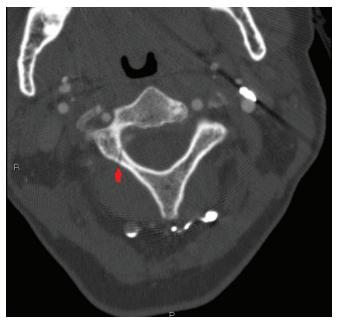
Axial computed tomography scan of the cervical spine of a 68-year-old woman who was struck by an electric scooter, showing a non-displaced fracture of the right posterior C2 arch, identified by the arrow.
